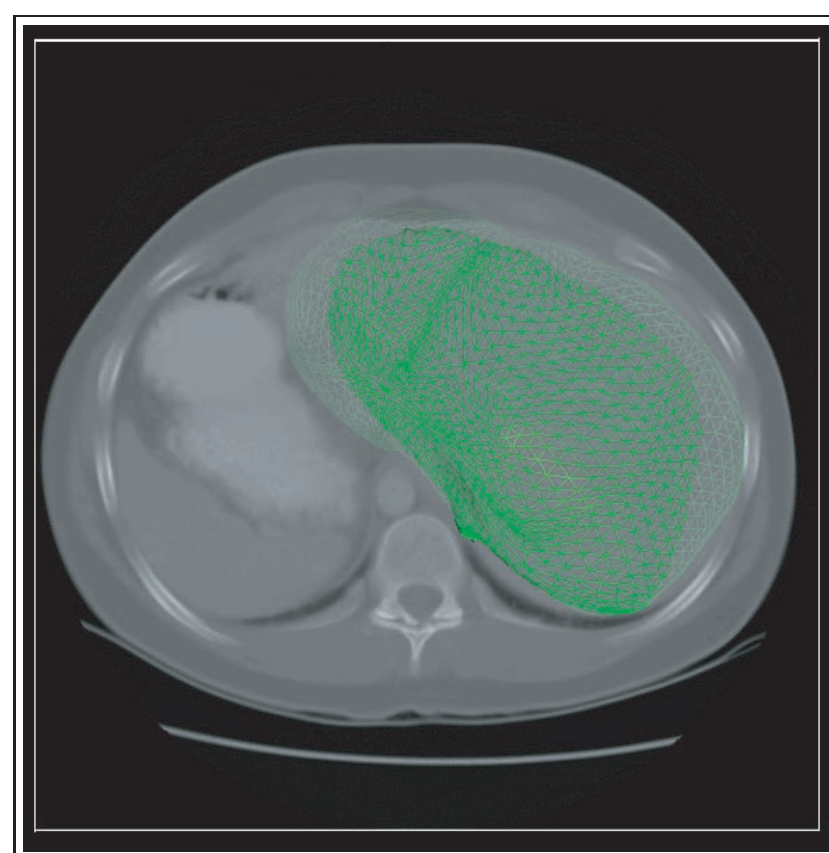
Deforming model on top of CT scan
